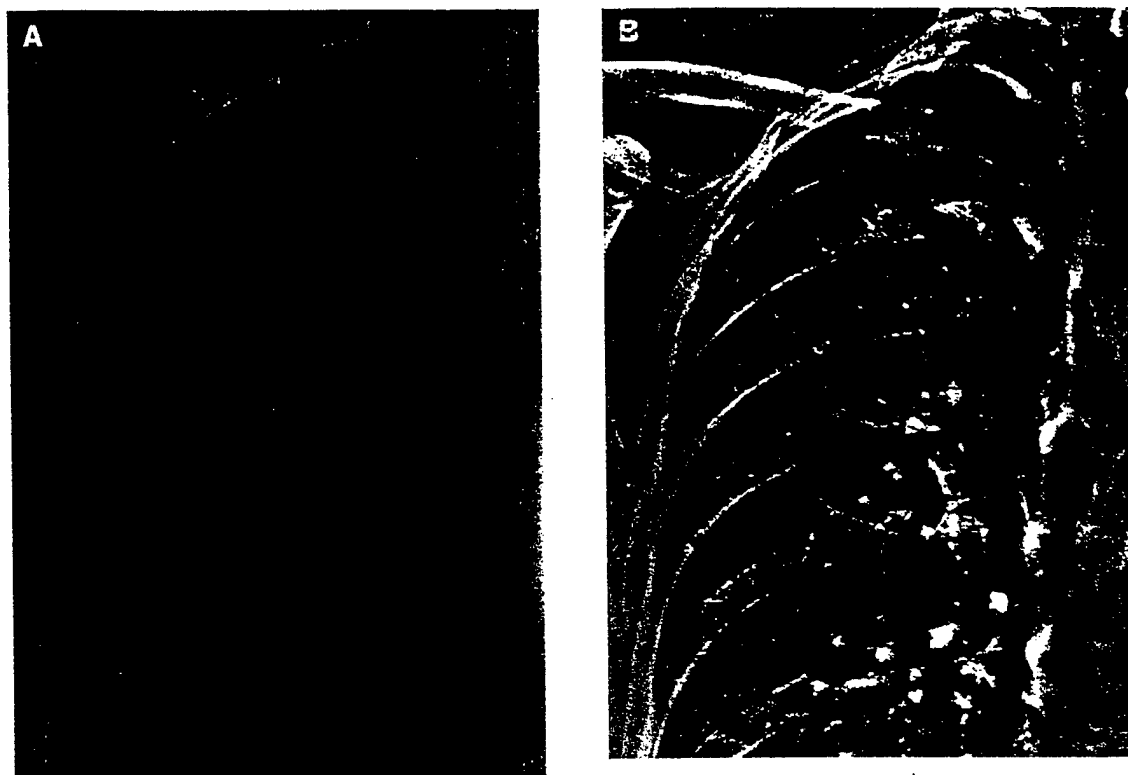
Image processing for edge enhancement, improving the demonstration of chronic obstructive pulmonary disease. (A) Standard enhancement image (GA = 0.6, GT = D, GC = 1.2, GS = -0.30, RN = 4, RT = R, RE = 0.5). These image processing terms are explained in the article "Image Processing in Digital Radiography" by Matthew Freedman that appears earlier in this issue of *Seminars in Roentgenology*. (B) Enhanced image. Edge enhancement increases the visibility of both normal and abnormal lung structures. The blebs and bullae can be seen more easily on the enhanced image (GA = 0.6, GT = D, GC = 1.2, GS = -0.30, RN = 0, RT = R, RE = 8.0).
